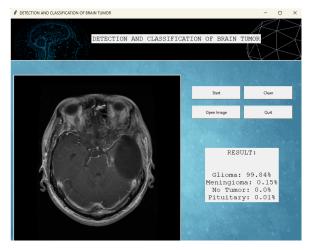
Prediction for a Glioma MRI image from the test set.
